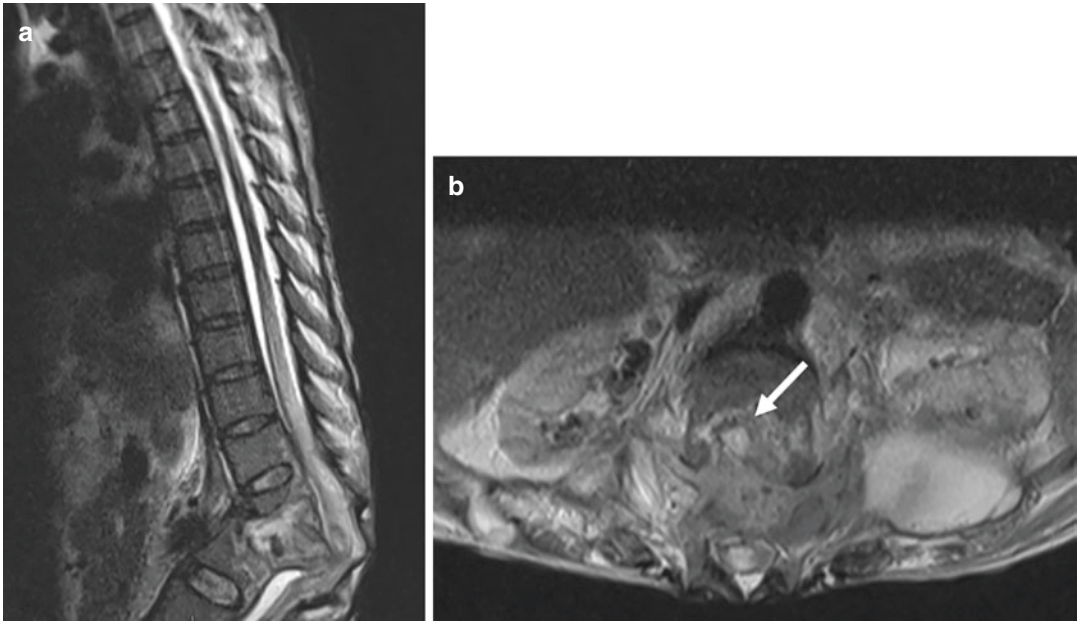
Spinal tuberculosis. (a) Sagittal T2-weighted MRI of the thoracolumbar spine demonstrates a kyphotic deformity secondary to tuberculosis infection in the spine.
